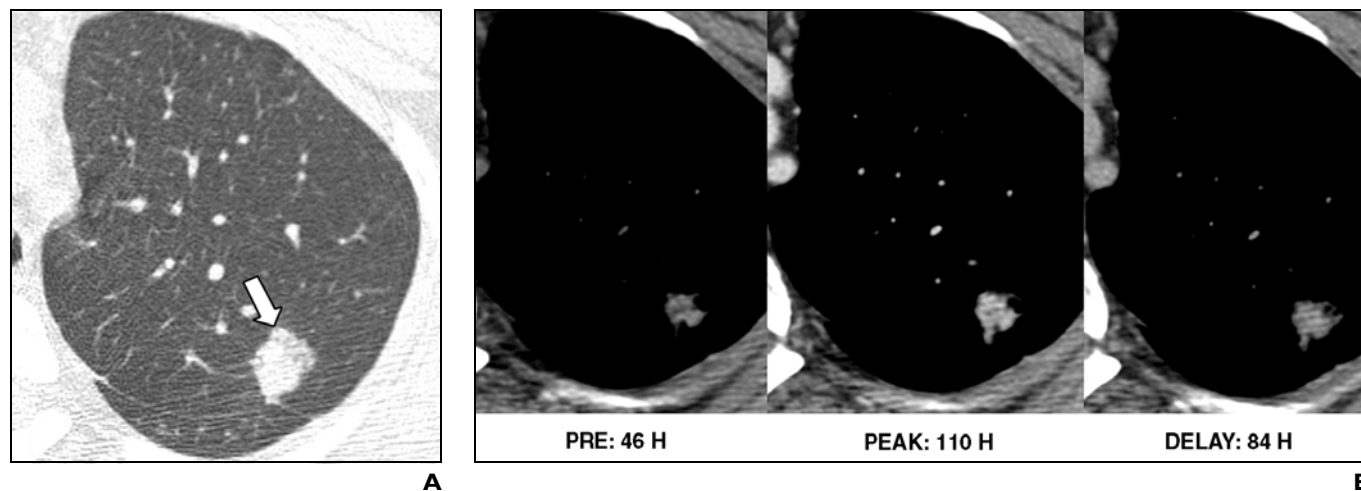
Adenocarcinoma with predominantly nonmucinous bronchioloalveolar carcinoma component in 49-year-old woman shows net enhancement of ≥ 25 H and washout of 5–31 H on dynamic helical CT but little ¹⁸F-FDG uptake on integrated PET/CT.
